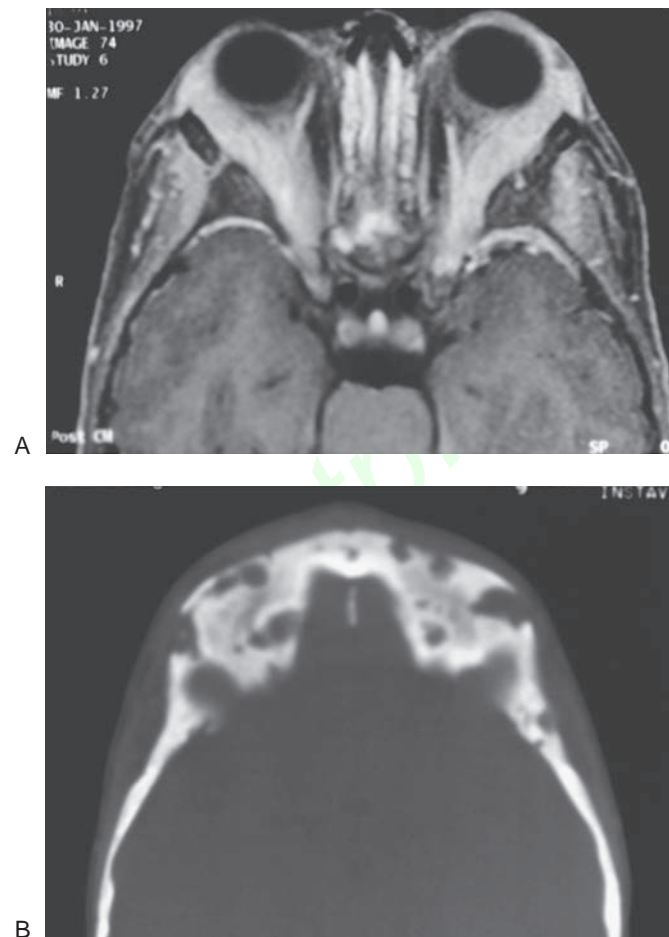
A: Axial magnetic resonance image of the orbits in a 4-year-old boy with recurrent disseminated Langerhans cell histiocytosis and marked proptosis. There are large orbital soft tissue masses bilaterally. B: Computed tomography scan of the same patient showing marked bony erosion of skull and orbit.
